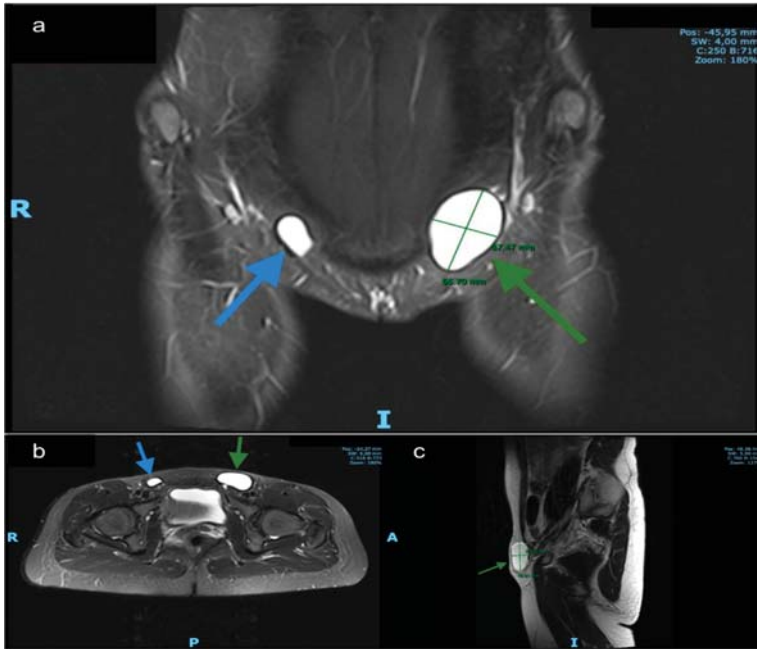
MRI findings. (a) Coronal T2-weighted. (b) axial T2-weighted and (c) sagittal MR images demonstrate a left inguinal hyperintense cystic structure without septation and a smaller (asymptomatic) on the right side. Green arrows: left hydrocele, blue arrows: right hydrocele.
